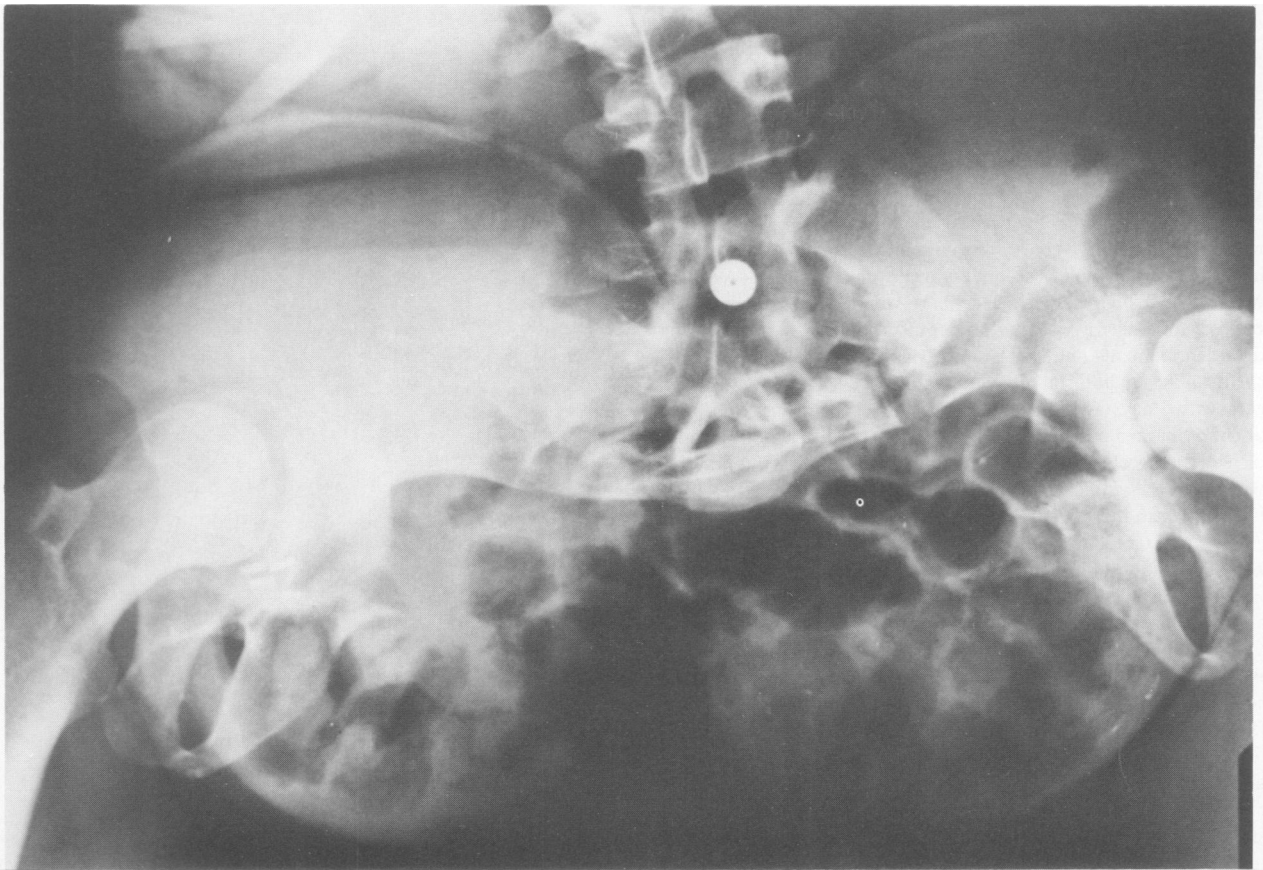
Radiograph demonstrating widely separated pubic symphysis at age 20 years.
